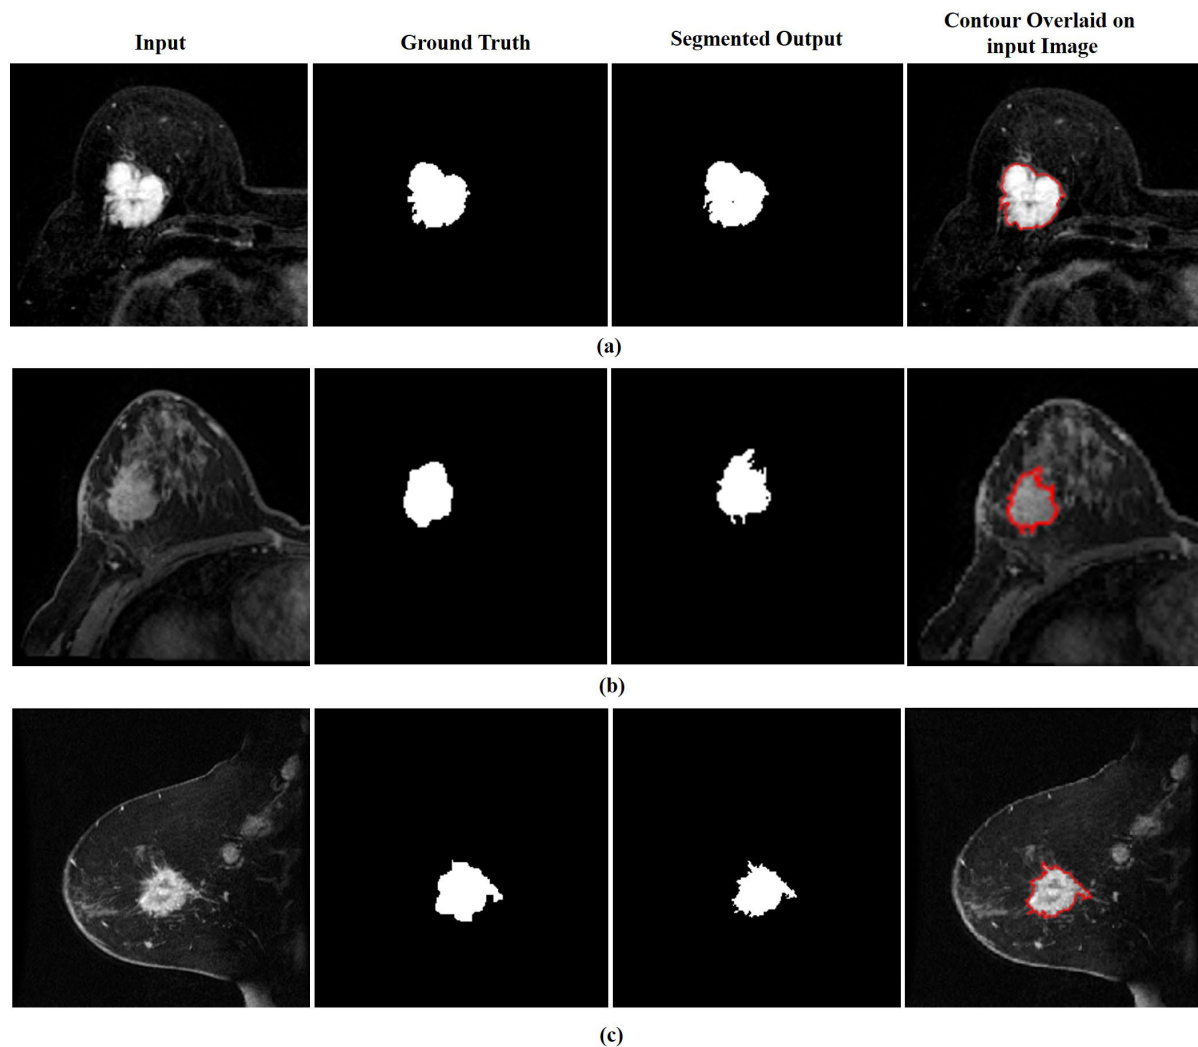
Representative DCE-MRIs demonstrating segmented output from various datasets. (a) BreastDM, (b) RIDER Breast MRI (c) ISPY-1.
